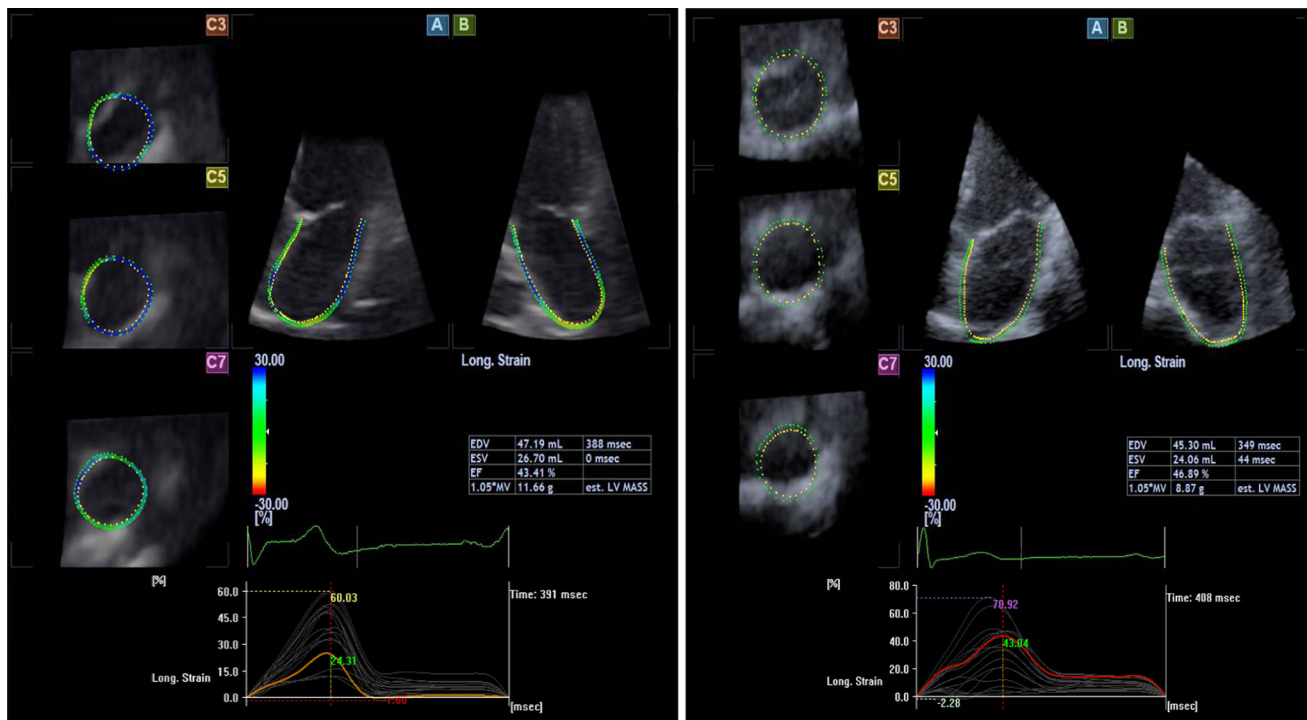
Left atrial longitudinal strain analysis using 3DSTE. Tracing of the LA endocardial border is performed from the base of the LA at the mitral valve level toward the LA apex, while excluding the LA appendage and the pulmonary veins from the LA cavity. Tracing was done in apical four-chamber view (A), apical two-chamber view (B), and three short axis planes (C3, C5, C7). The frame of LV end-systole
